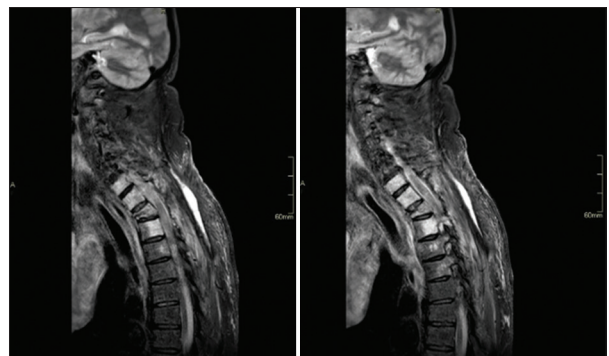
Magnetic resonance imaging images confirming cord compression at T1–T3 levels
